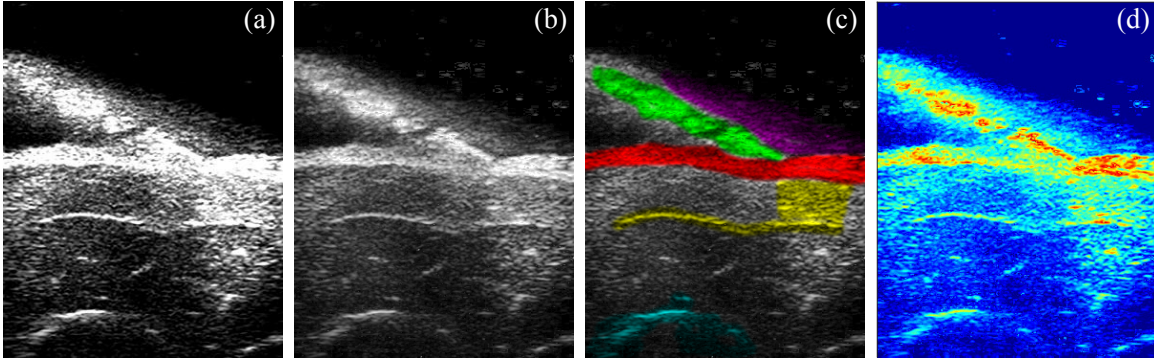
(a) Ultrasound image acquired at 0.0 dB. (b) Tone mapped HDR-US image. (c) Regions discussed in the text. Highlighted in green is the ablation catheter body, purple is the ringing from the catheter, red is the fat layer, cyan is the bone, and yellow is the deep tissue structure. (d) HDR-US image intensities before tone mapping, shown in false color to convey the entire dynamic range. This image contains over three orders of magnitude of dynamic range, from 0.09 to 140.
